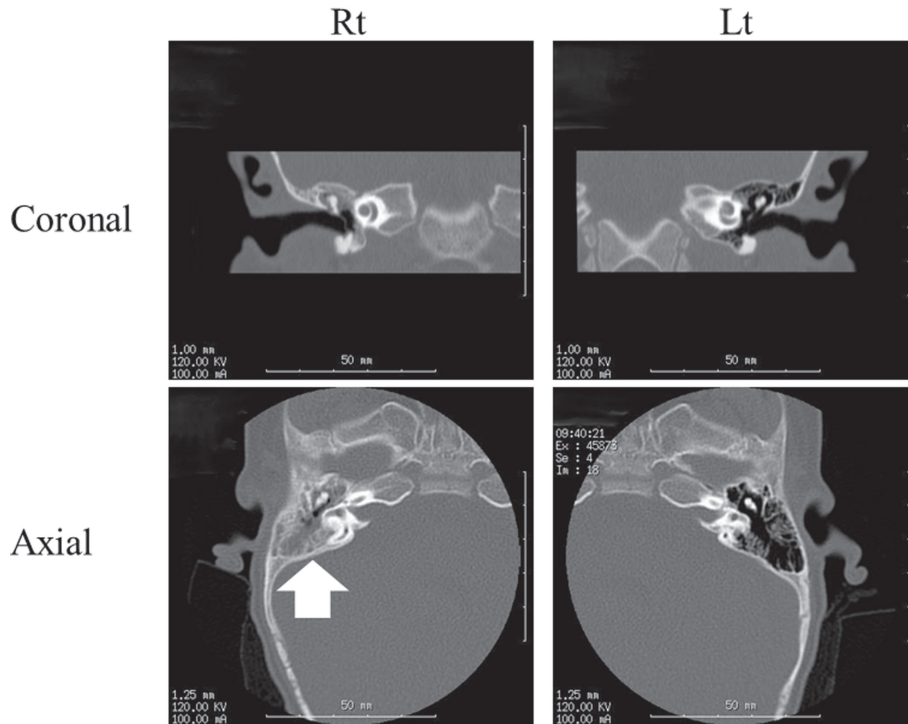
Temporal bone CT
